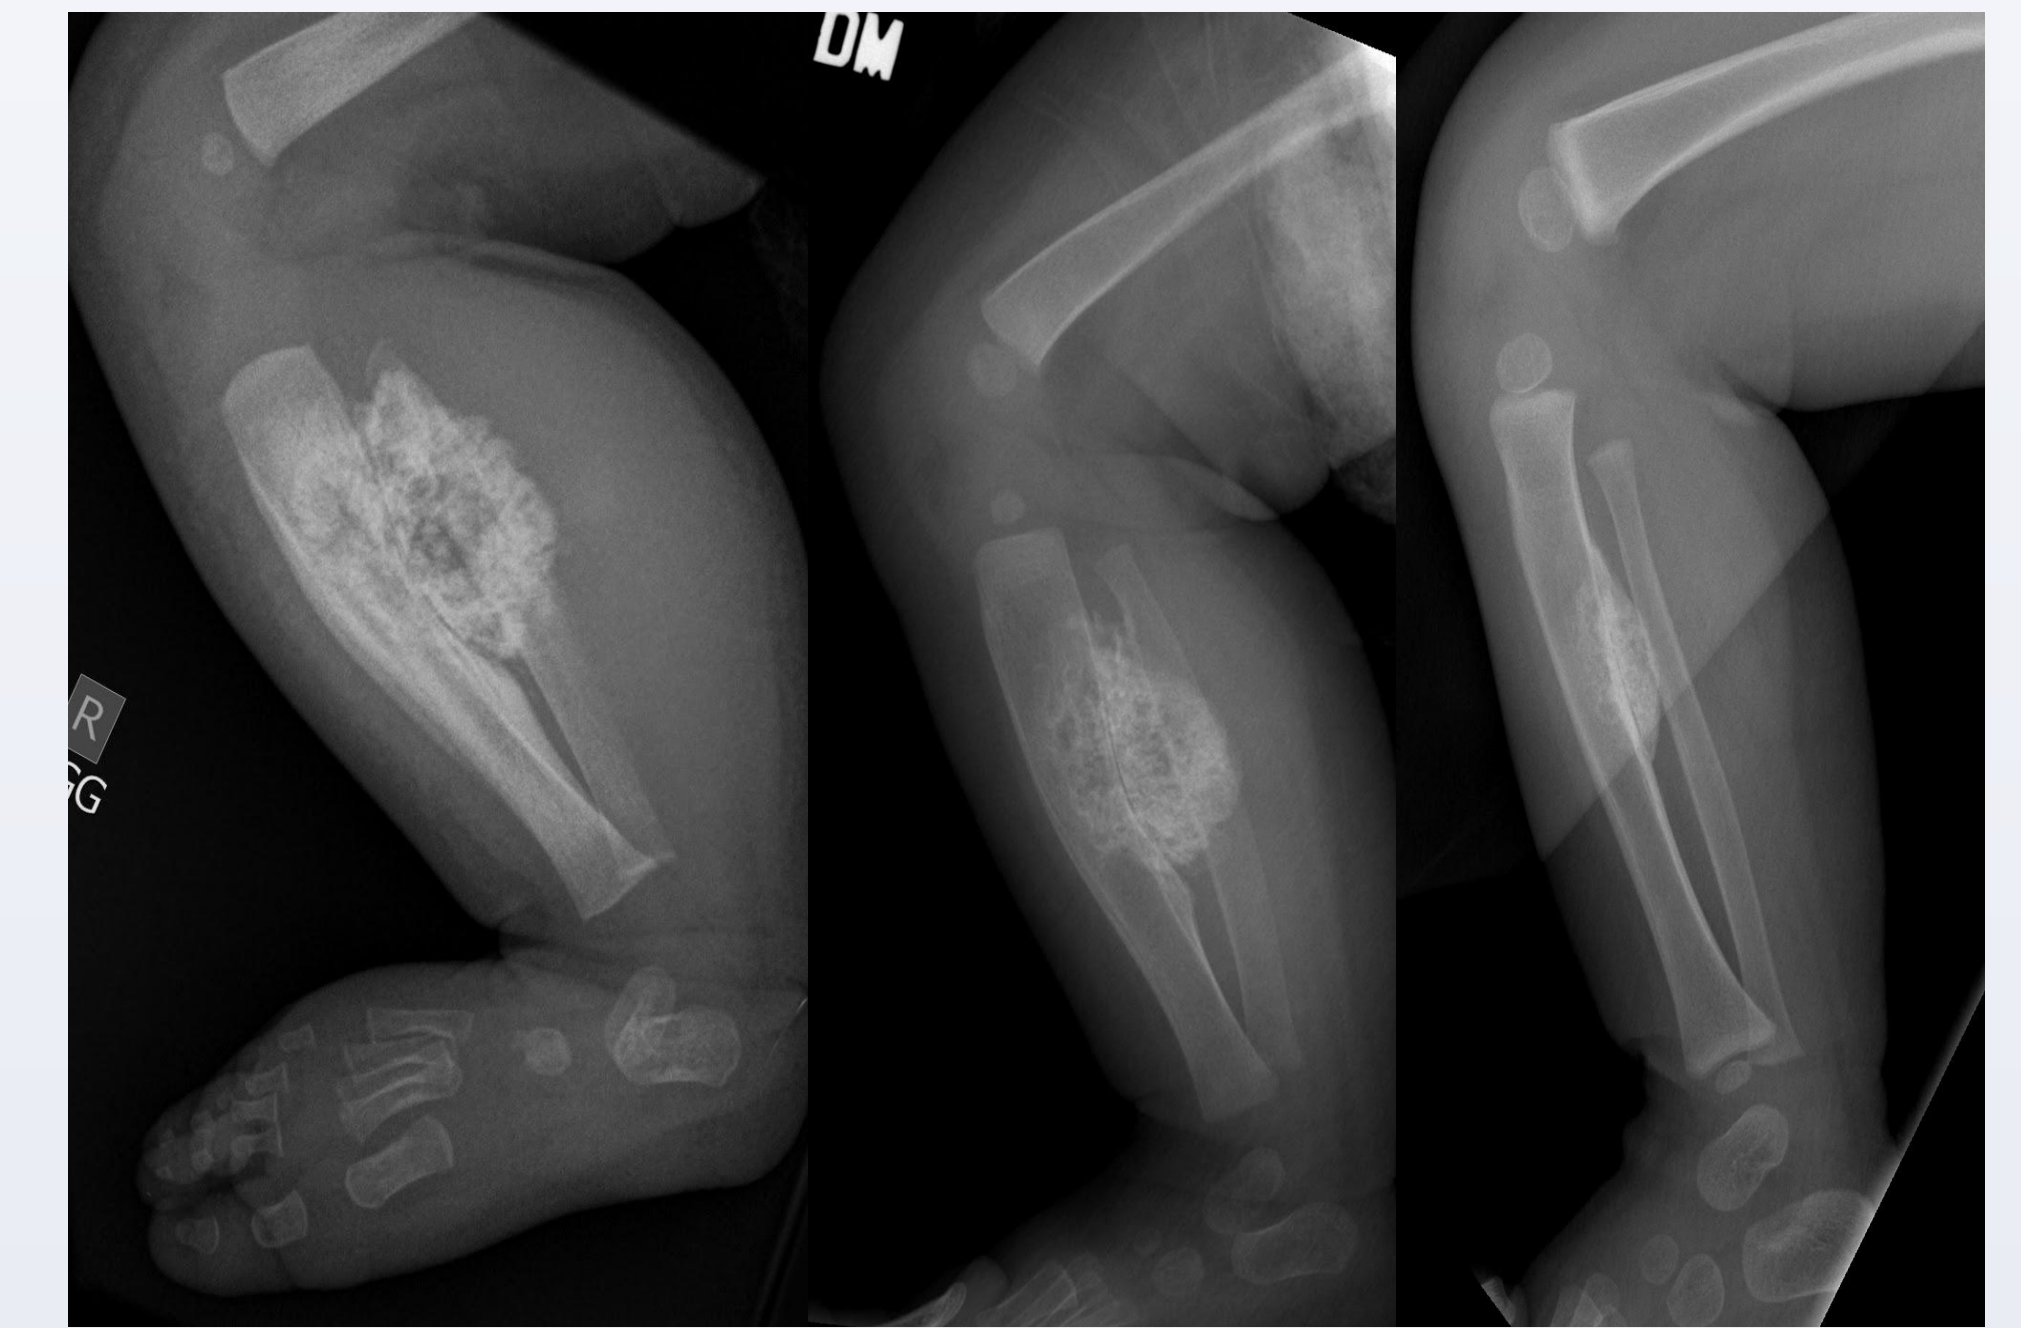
Serial Frog-leg view radiographs of the right leg demonstrating that the mass gradually decreases in size over approximately 15 months
